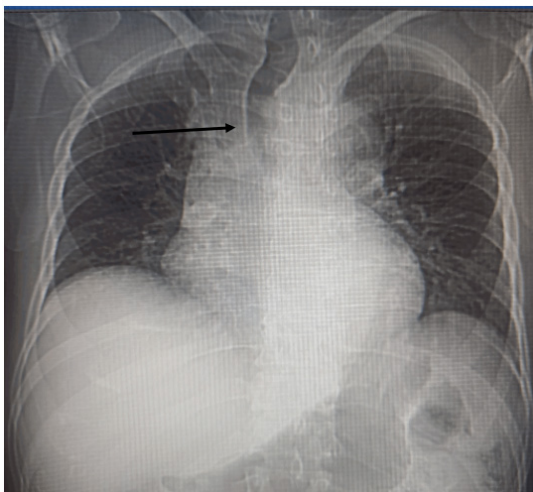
Tracheal deviation in the chest radiography marked with an arrow.
